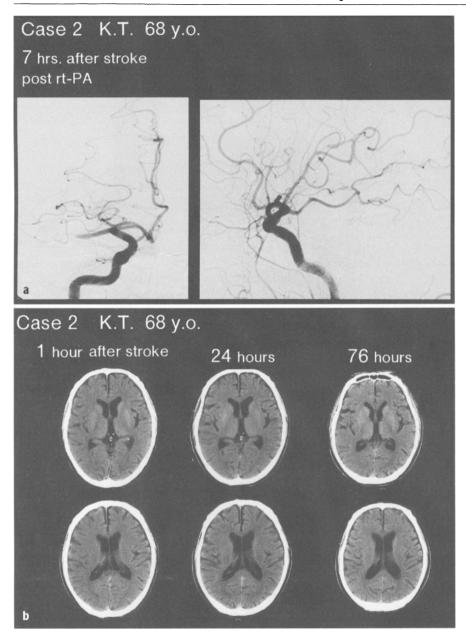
a Angiography of occlusion in case 2. b Serial CT showing lack of ischemic damage in case 2
